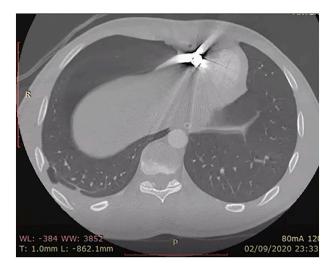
CT scan (axial view) executed on the first postoperative day showing the location of the projectile.
